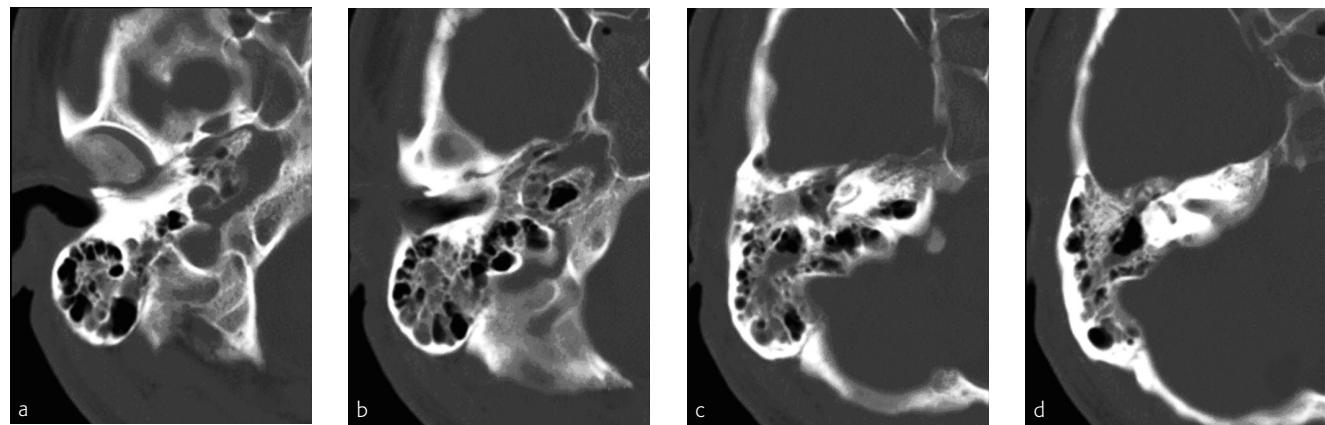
Head CT of patient with a right longitudinal temporal bone fracture and delayed onset, incomplete right facial palsy.
